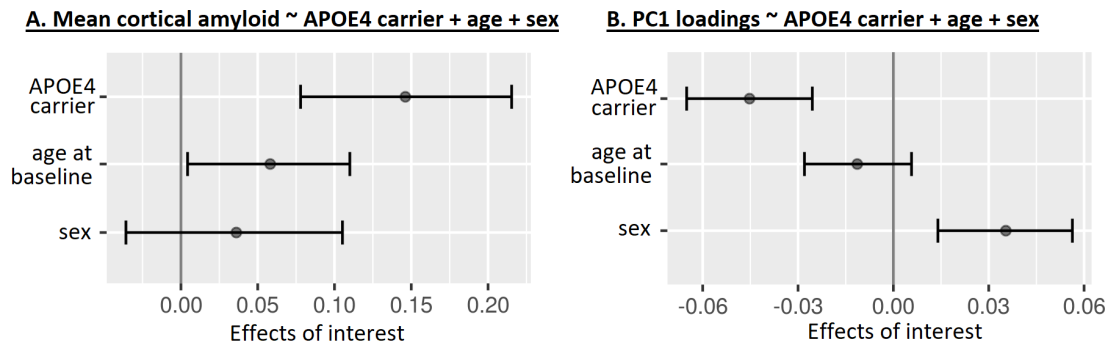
Effect sizes of APOE- ϵ 4 status (carrier) and nuisance predictors of age and sex, obtained from Bayesian regression investigating mean cortical SUVR and PC1 loadings. (A) APOE- ϵ 4 was (A) positively associated with mean cortical SUVR, and (B) negatively associated with PC1 expression. This is in line with the same relationship found between these measures and conversion to dementia given in figures 6.7[A] and 6.8[A].
